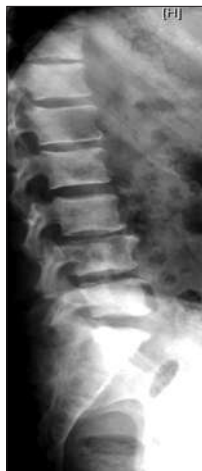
Radiograph of lumbar spine showing osteosclerotic vertebra
